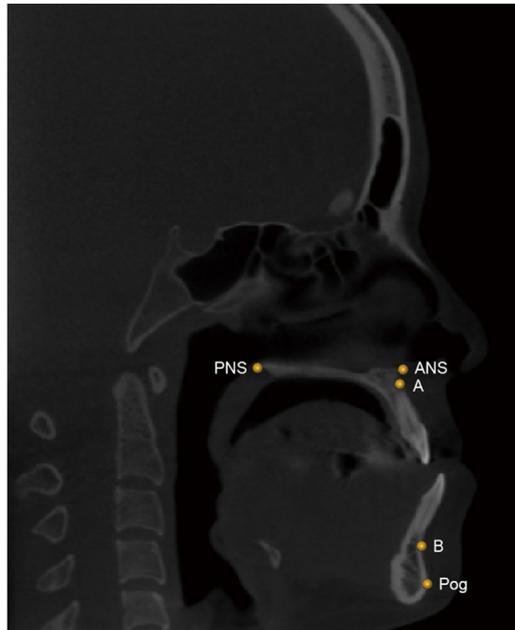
Skeletal landmarks on a midsagittal cone beam computed tomography scan: anterior nasal spine (ANS), posterior nasal spine (PNS), point A, point B, and pogonion (Pog).
